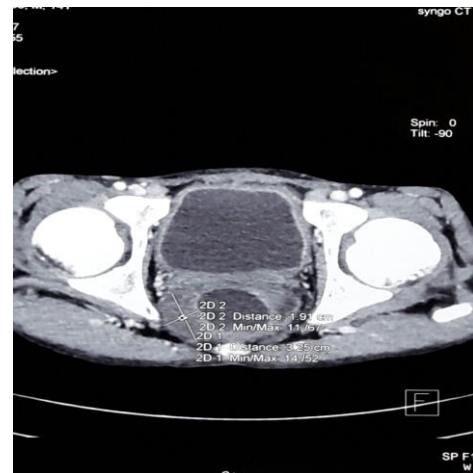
CT scan showing a significant decrease in the rectal tumor process, more marked at the right parietal level.
